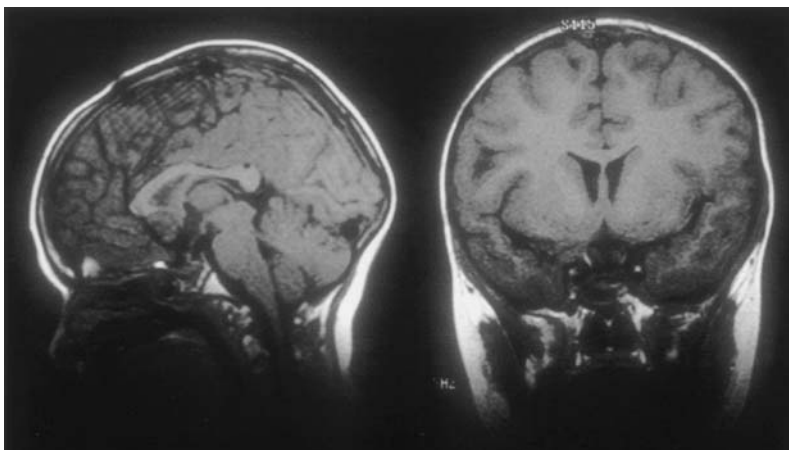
Sagittal (left) and coronal (right) MRI (T1), showing a suprasellar germinoma. Typically located in the midline, the pineal region is also a common location for germinomas.
